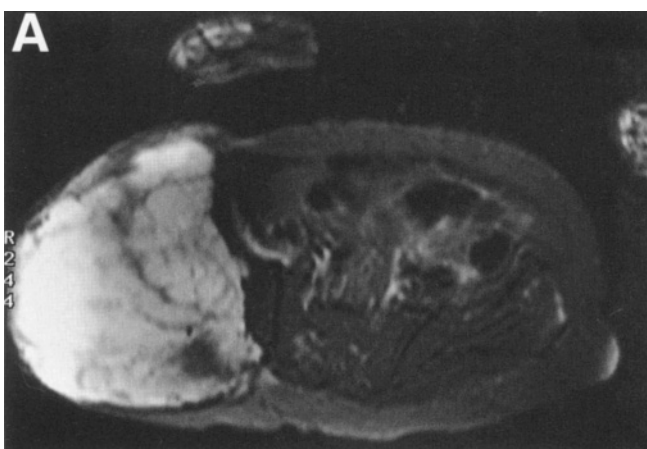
MRI scan of an extremely large chondrosarcoma arising from the wing of the ilium and the periacetabular bone. (A) The high-intensity area represents gross tumor permeating through the ilium. Note that there is no intrapelvic extension. (B) The large soft-tissue component is seen arising from the underlying ilium. It involves the sacral alar and the SI joint. This tumor is inoperable.
